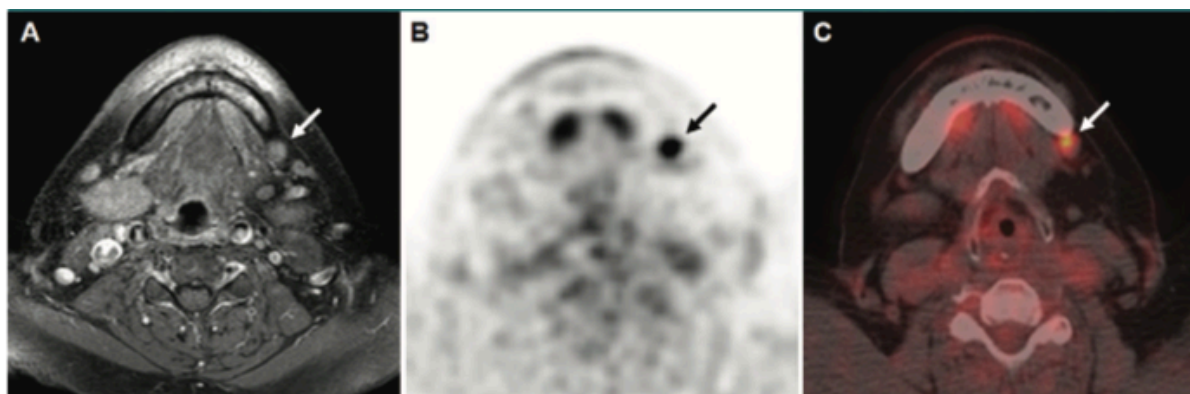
Images show preoperative detection of metastatic lymph nodes in a 66-year-old woman with oral cavity cancer and negative neck palpation findings. A, T1-weighted gadolinium-enhanced MR image shows an oval lymph node (arrow) in the left cervical level II; its size suggests falsely that it is a benign node. B, ^{18}F -FDG PET and C, fused PET/CT images show a true-positive finding with strong ^{18}F -FDG uptake (arrows).
